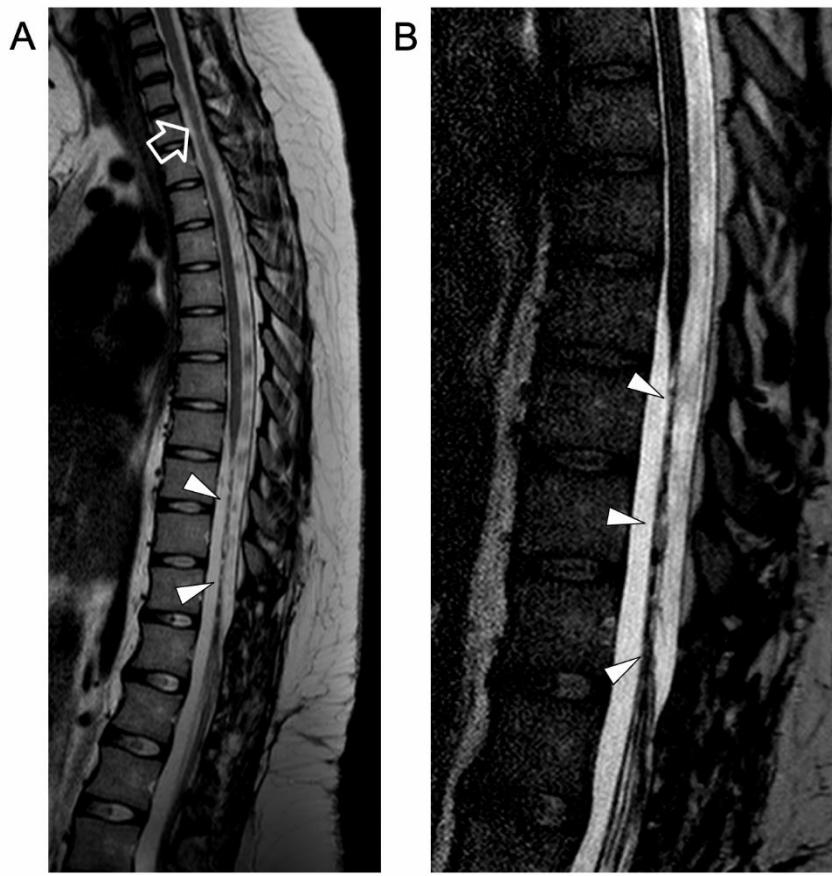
Contrast-enhanced spinal MRI performed at last follow-up, several months after clinical onset. Sagittal T2-weighted (A) and 3D driven equilibrium (DRIVE) (B) images reveal a focal area of mild spinal cord thinning at the superior dorsal level (empty arrow) and an extended segment of severe spinal cord atrophy in the inferior dorsal spinal level (arrowheads).
